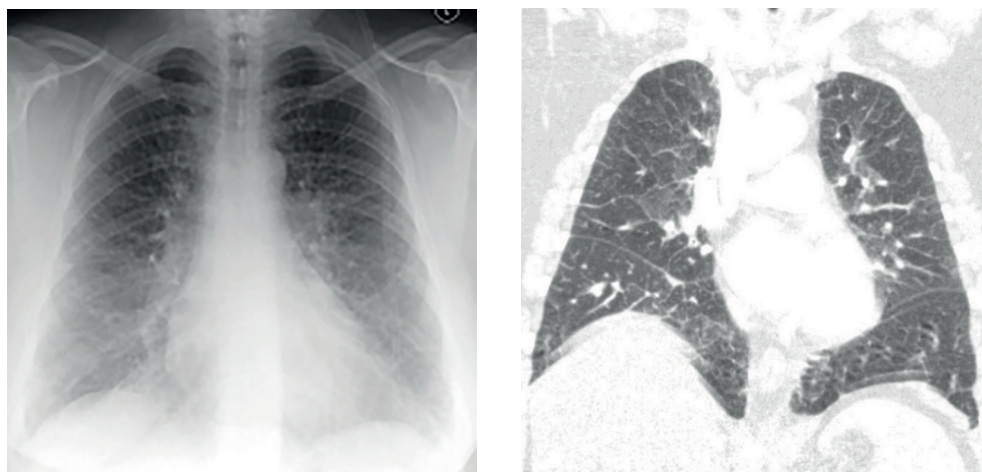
An example of nitrofurantoin-induced pneumonitis: (A) chest X-ray shows a diffuse reticular pattern: (B) High-resolution computed tomography (coronal slice) confirms this reticular pattern, which is caused by thickening of the interlobular septa.
